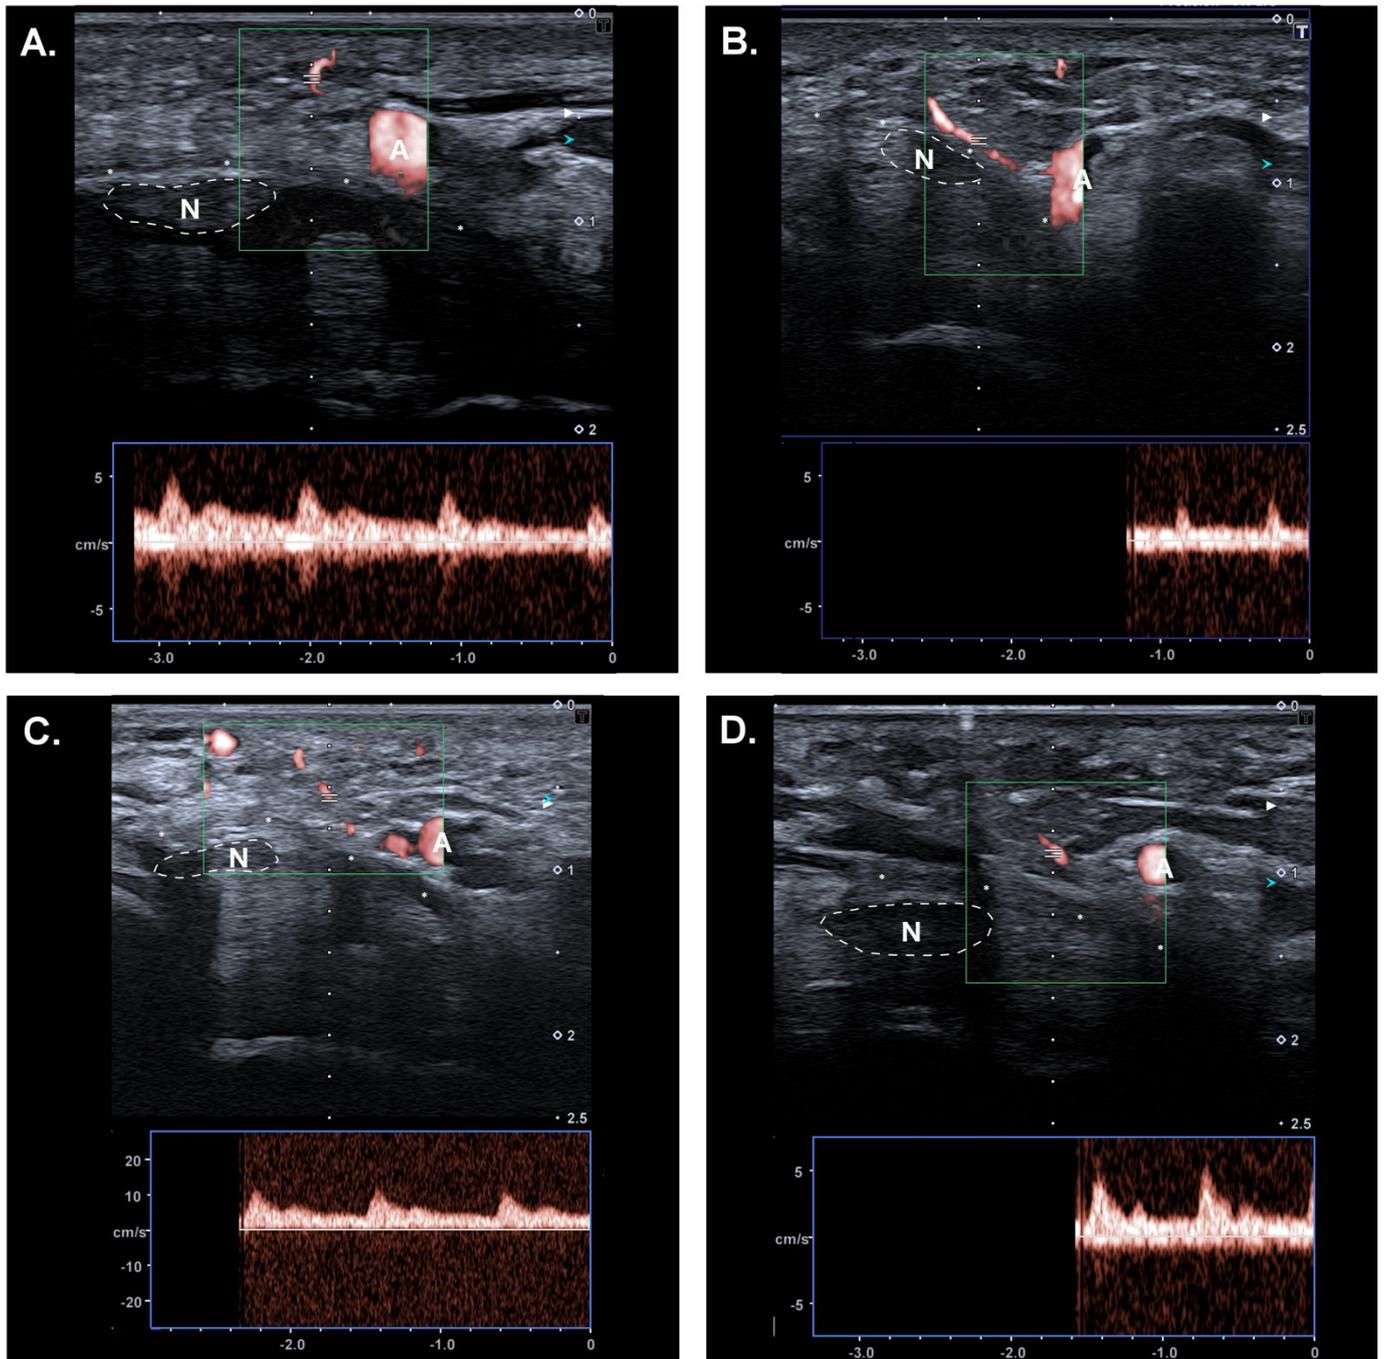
Examples of micro-vessels detected in SMI and confirmed in Pulsed Doppler in the Safe Zone, on the superficial side of the retinaculum in 4 different patients. N: median nerve; A: ulnar artery; asterisks: flexor retinaculum.
